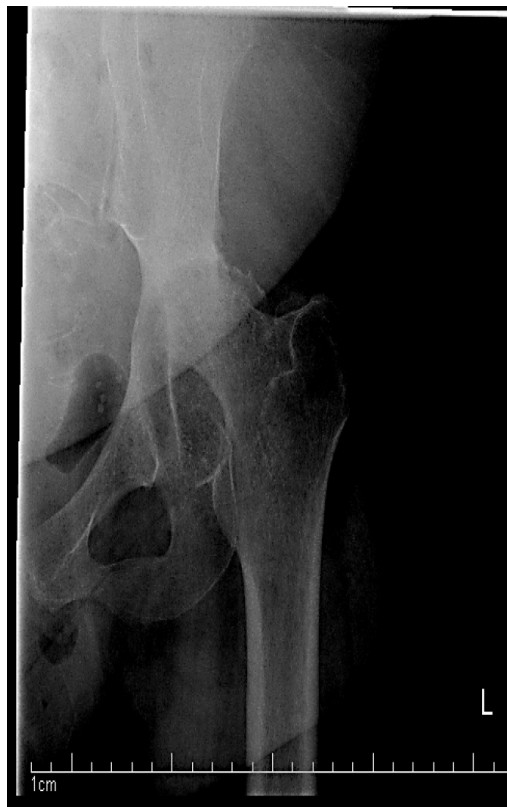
Single AP view Xray of the left hip: Nonvisualization of the left femoral head which represent resorption of the femoral neck.
